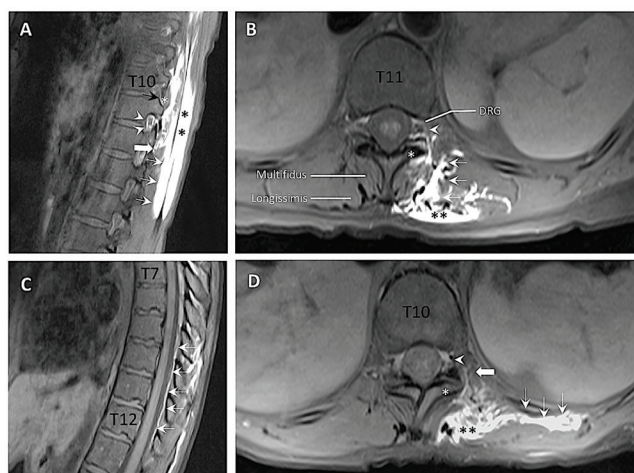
MRI of the spine showing injectate spread 1 hour after injection of 30 mL of local anesthetic and gadolinium contrast at the T10 transverse process in a patient with chronic abdominopelvic pain. (A) Parasagittal view showing spread of injectate (white line arrows) to the erector spinae muscles (*), paravertebral space (bold arrow), and neural foramina (arrowheads). The facet joint and the inferior articular process are indicated by a black arrow and white asterisk, respectively. (B) Axial view at the level of the T11 vertebra. Injectate (line arrows) has penetrated throughout the erector spinae muscle (black asterisks). The arrowhead indicates the intervertebral neural foramen, where the dorsal root ganglion (DRG) of the spinal nerve is located. The inferior articular process is indicated by a white asterisk. (C) Another parasagittal view showing injectate within the posterior epidural space (line arrows). (D) Axial view at the level of the T10 vertebra. Injectate has spread to the intercostal space (line arrows). The neural foramen (arrowhead), paravertebral space (bold arrow), erector spinae muscle (black asterisks), and inferior articular process (white asterisk) are indicated. (adapted from Schwartzmann *et al*⁷⁸ with permission from Philip Peng Educational Series)
